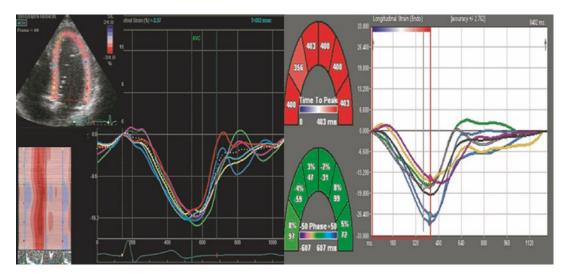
These are two strain recordings from the apical four-chamber view from a normal individual by two manufacturers systems. The interfaces are different and colors are different. Unfortunately, there is no agreement
